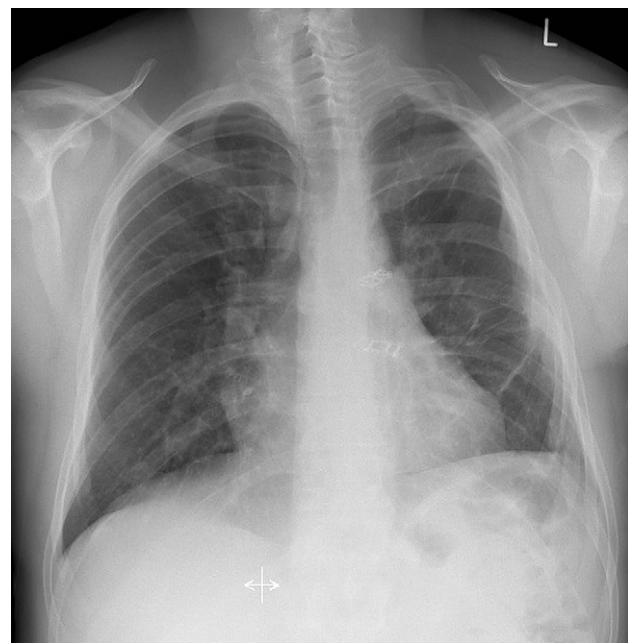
Post-operative PA chest radiograph showing restored intercostal spaces.
